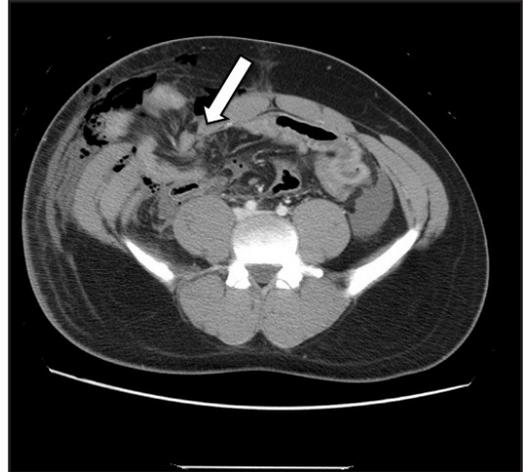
Abdominal CT showing a herniation of a loop of small bowel through a 4.5cm x 4.5cm defect in the right rectus abdominis (arrow)
